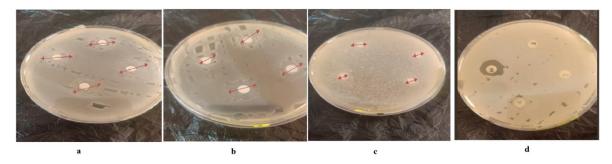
results of the microbial strains tested in E-coli (a: Tablet PEG/EC, b: Tablet EC, c: Tablet CTA/EC, d: Antibiograms)
